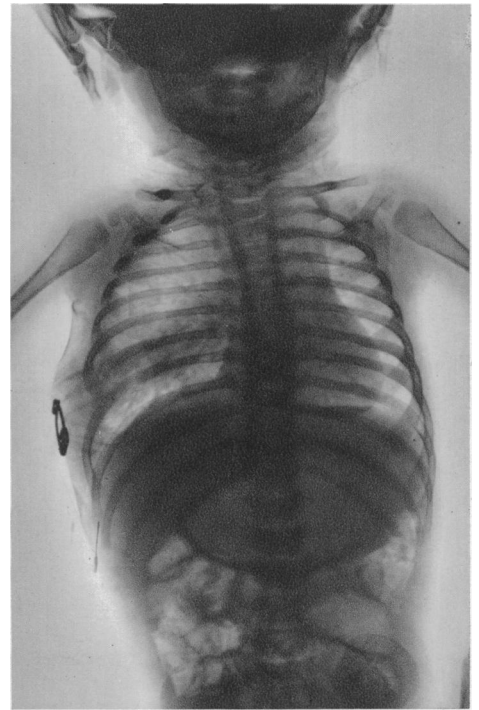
Radiograph taken on September 24, 1936.
